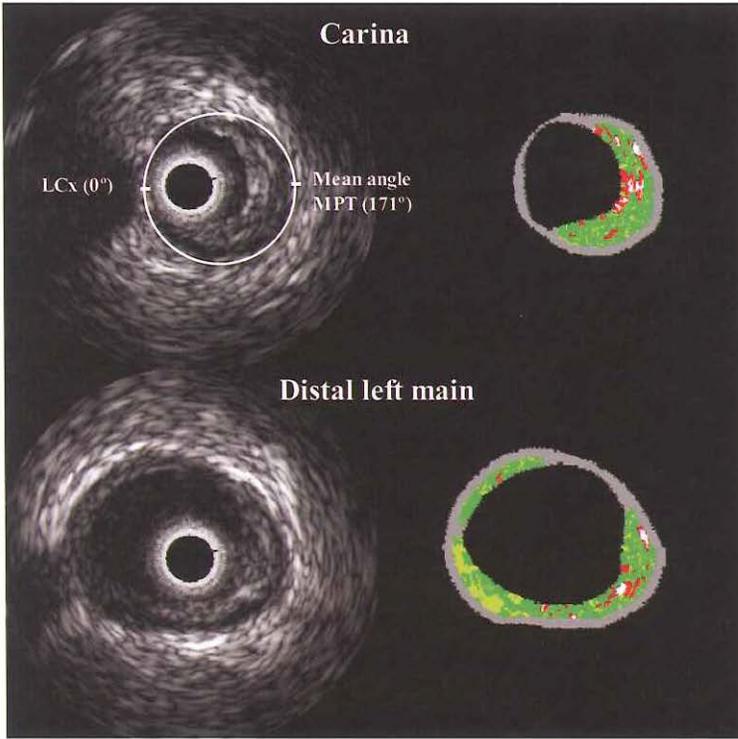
Intravascular ultrasound cross-section images from the carina of the left anterior descending coronary artery and of the left main coronary artery. The left side shows the reconstructed grayscale, and the right side shows the color-coded data (green = fibrous; yellow-green = fibrolipidic; red = necrotic core; white = calcium) provided by the IVUS-VH unit (Volcano Therapeutics, Rancho Cordova, California). LCx = left circumflex artery; MPT = maximal plaque thickness.
